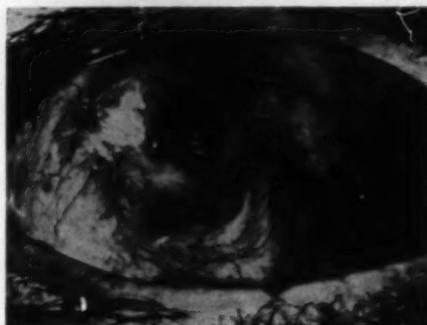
(Leahy). Epidermoid carcinoma involving corneal and bulbar conjunctiva. Low-voltage X-ray therapy is indicated here rather than any type of applicator. By X rays the entire area can be radiated without resort to the dangerous overlapping of treatment areas. Since overlapped areas may receive double dosage, they may ulcerate years later.
